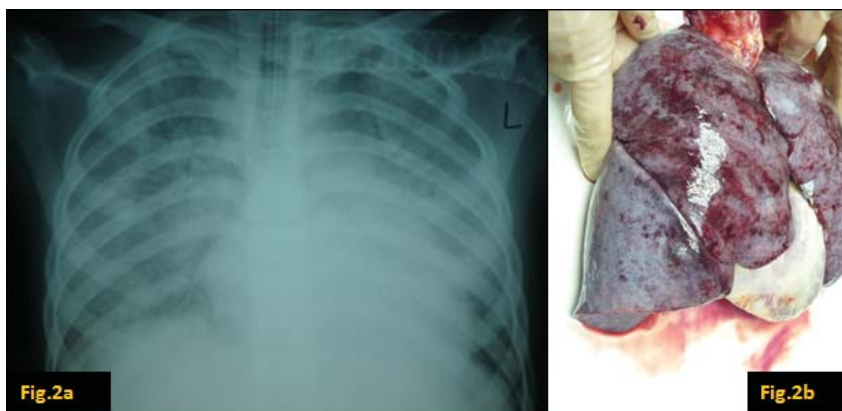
Macroscopic and X-ray findings: a) Massive bilateral shades of the lung parenchyma; b) bilateral total suppuratory haemorrhagic bronchopneumonia
